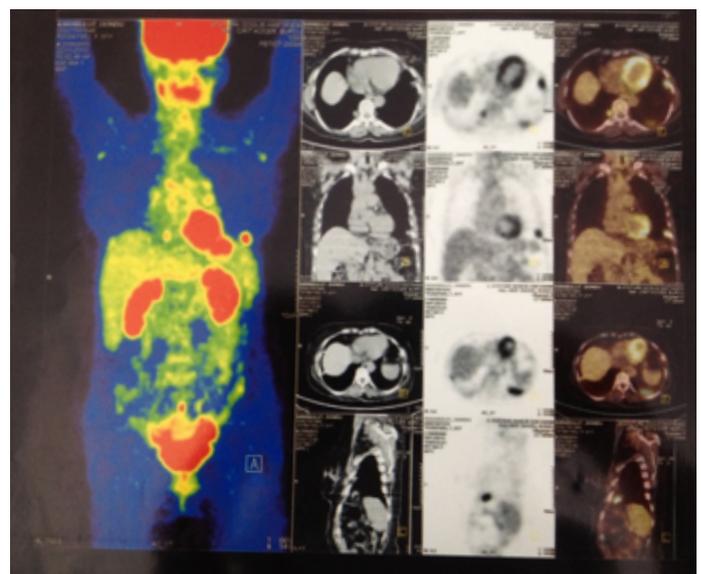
An 8.7x7.1 cm mass with increased FDG uptake (SUVmax: 19.53) in the middle lob. Focal collaps/consolidation viewed in lingula (SUVmax: 13.52).
